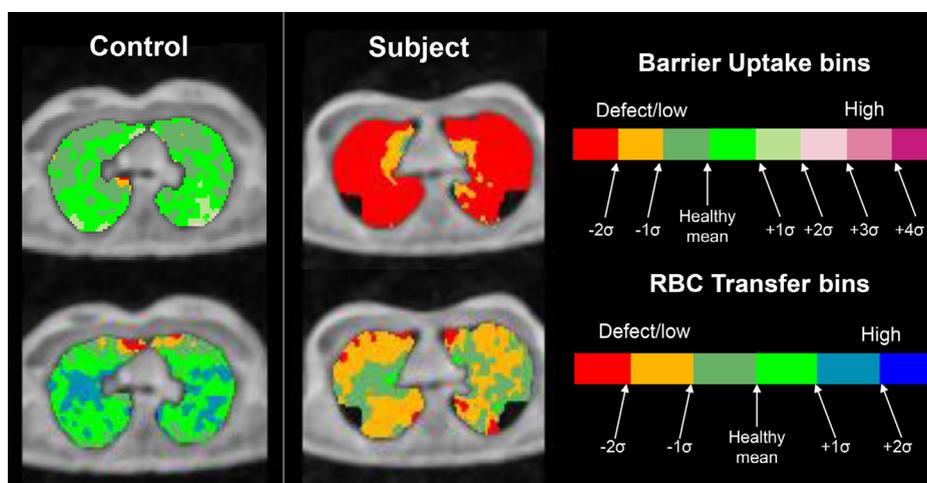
Axial ¹²⁹Xe magnetic resonance imaging gas-exchange maps show very low interstitial signal (top), compared with young-adult controls (ages 26 and 29 years) leading to a lower transfer to red blood cells (bottom); low values for Xe gas exchange are consistent with increased airspace size indicated by elevated apparent diffusion coefficient in [Figure 1](#).
